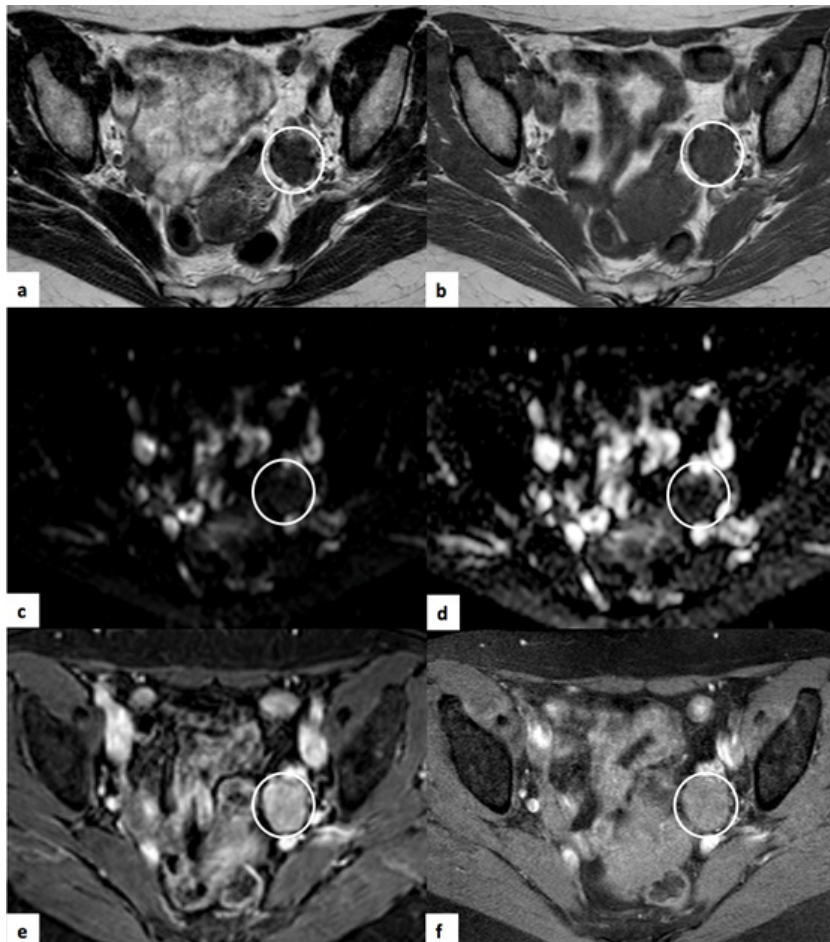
Brenner tumour of the left ovary. Pelvic MRI of 58-year-old woman. (a) Axial T2-weighted image, where a small solid tumour of the left ovary is shown, with marked T2 low signal. (b) T1-weighted image, where the tumour is isointense with the muscle. (c) and (d) DWI ($b=1000$) and ADC map, respectively, where it can be seen that there is no restricted diffusion. On the axial T1-weighted image after intravenous contrast T1 SPAIR (e) and on the delayed axial acquisition SPIR (f) there is moderate enhancement, which is more expressive than the usual for fibromas and thecomas (suggestion: comparison with Fig. 9e).
